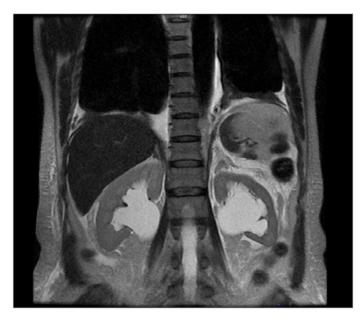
Abdominal MR image of pelvicaliectasis. Detection of pelvicaliectasis changed the course of diagnosis and treatment.
